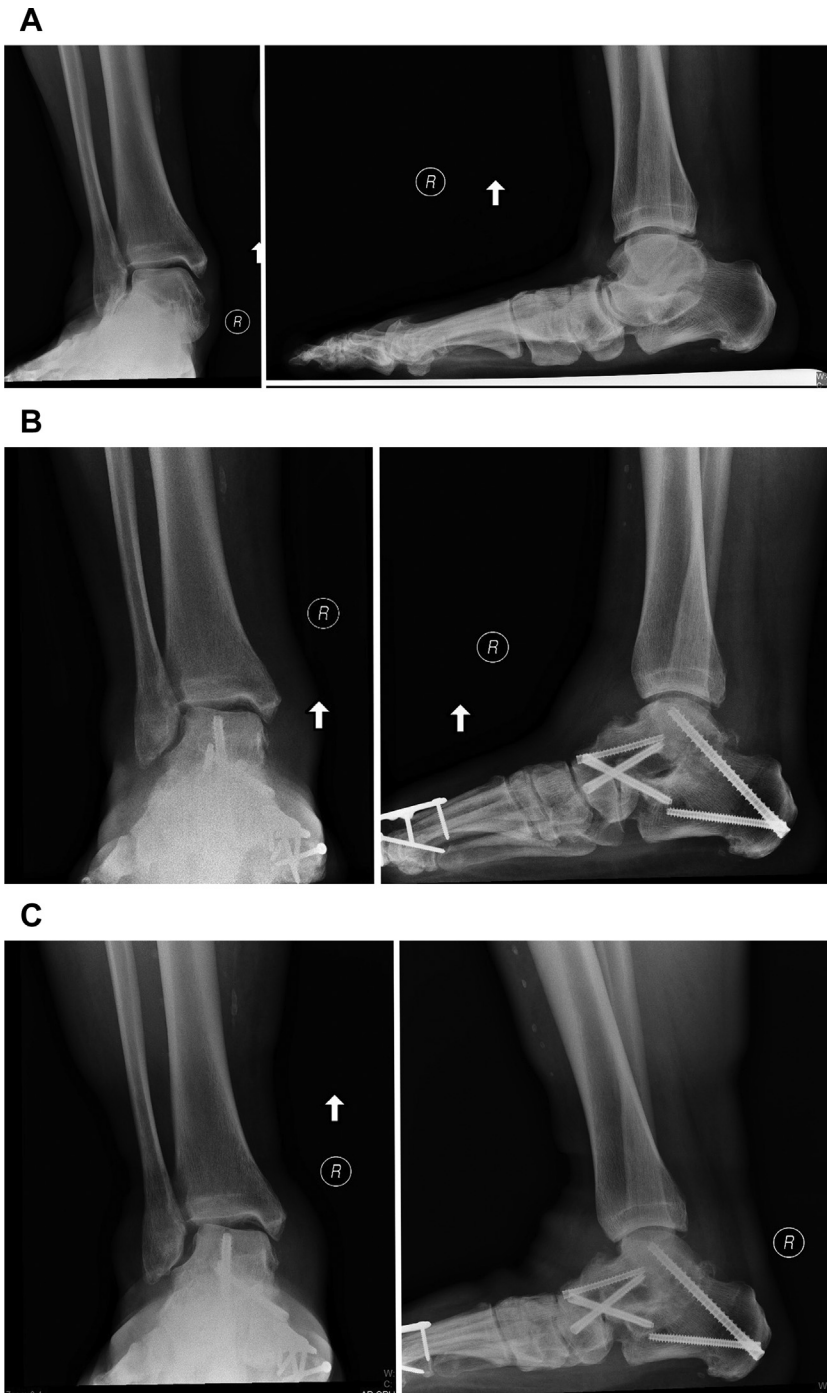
Preoperative AP ankle and lateral foot radiographs (A) of a patient with hallux rigidus combined with a symptomatic severe pes planus deformity. Note the mild ankle valgus on the AP radiograph. Because of the severe hindfoot instability and early arthritic changes noted on CT scan, a triple arthrodesis, first metatarsophalangeal (MTP) arthrodesis, with an Achilles lengthening was performed. In addition, in an attempt to minimize the risk of ankle
